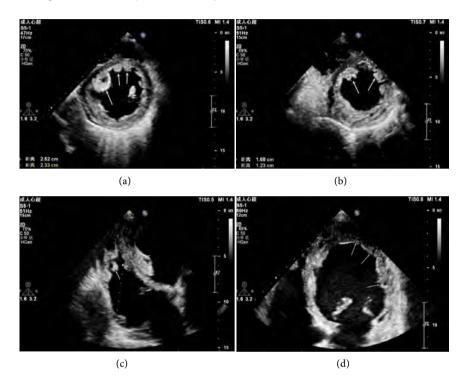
Transthoracic echocardiography demonstrated massive thrombus formation (arrow) within left ventricular cavity (a), significantly reduced thrombotic masses after two days of anticoagulation therapy in left and right ventricular cavity (b and c), and delayed revealed severe non-compacted myocardium with excessive trabeculae and deep recesses after six days of anticoagulation therapy (d).
